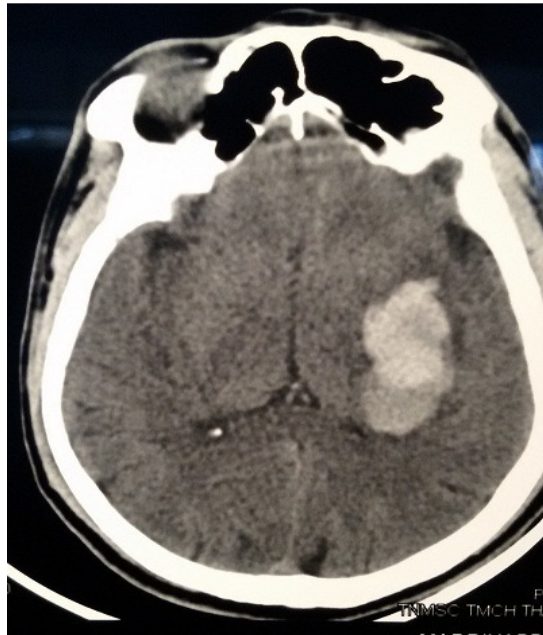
NON CONTRAST CT BRAIN SHOWING ACUTE LEFT
